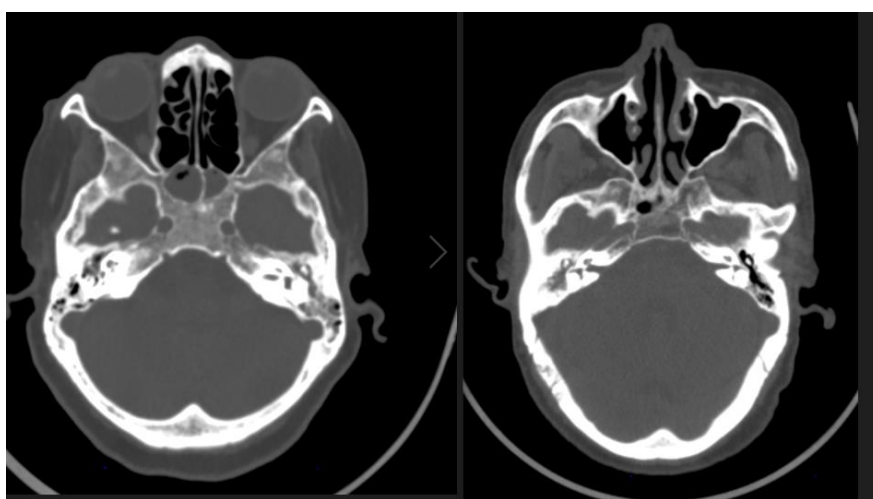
Types of CT scan done in TASH patients with incidental mastoid air cell opacification, 2022G.C., Addis Ababa, Ethiopia.
